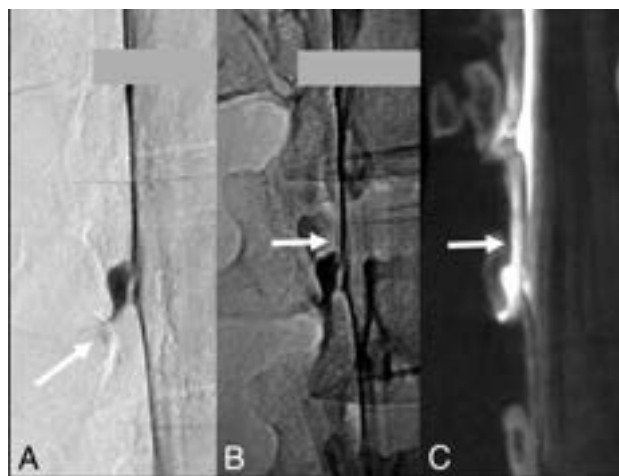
A 26-year-old woman severely impaired by SIH. DSM with the patient in a right lateral decubitus position shows a small but remarkable diverticulum at the L1/2 level. A subtle contrast flickering is visible at the bottom of the diverticulum (arrow in A). Delay single x-ray shows a faint hyperdense line as a questionable indication of extradural contrast outflow (arrow in B). Subsequent CBCT in a coronal reconstruction confirms the findings as a type 2 leak (arrow in C). CBCT settings are the following: 3D-(4sDCT Body Care) 49-cm zoom, 90 kV, 404 mA, 90 images/sec in 3.53-second runtime (248 total images).
